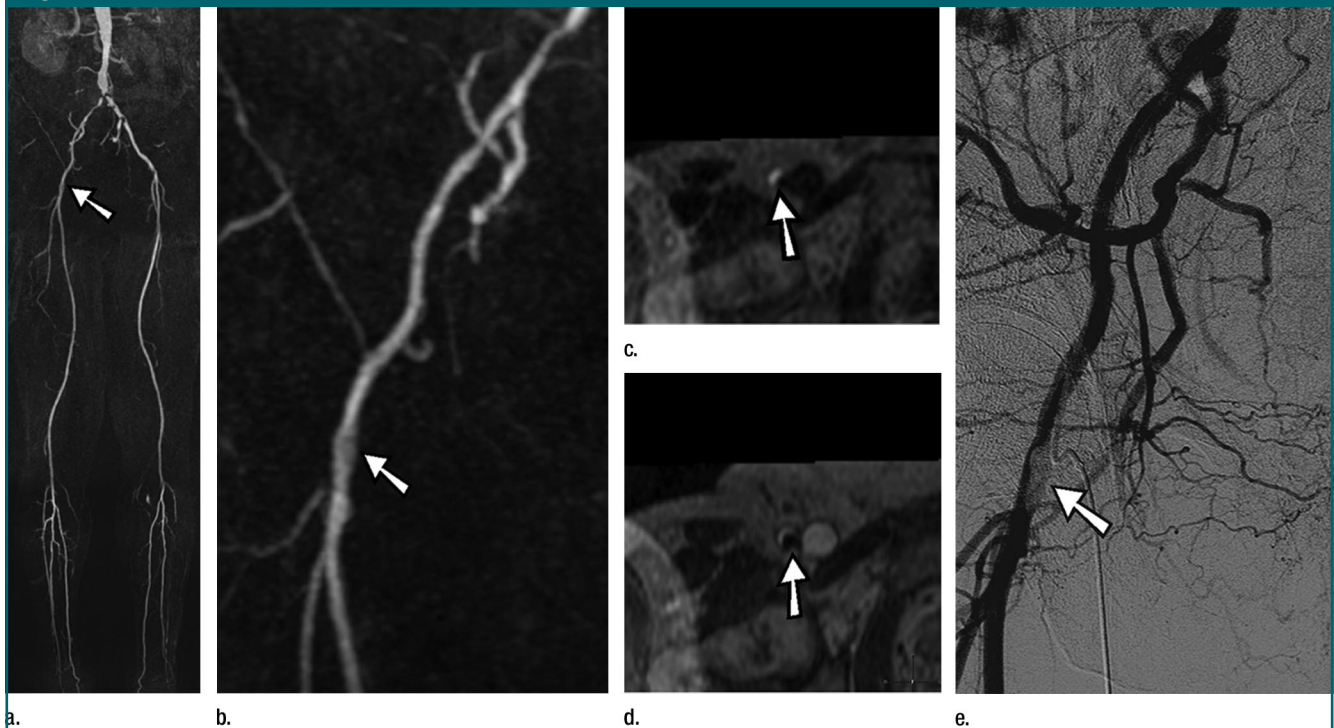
MR angiographic and DSA images of high-grade stenosis of common right femoral artery (arrow) in a 72-year-old man with severe aortoiliac occlusive disease. (a, b) Fused maximum intensity projections of moving-table-subtracted contrast-enhanced T1-weighted gradient-echo images (2.7/0.89) during the arterial first pass. (c) Cross-sectional multiplanar reformation of contrast-enhanced T1-weighted gradient-echo images (4.8/1.42) during the steady state. (d) Cross-sectional multiplanar reformation of high-spatial-resolution contrast-enhanced T1-weighted gradient-echo images (4.8/1.42) during the steady state. (e) Anterior view of DSA of right pelvic arteries. Stenosis grading of right common femoral artery (arrow) was judged as less than 50% on first-pass MR angiogram, but 50% or higher on steady-state MR angiogram and DSA image. Note the vast underestimation of stenosis grade on a and b.
